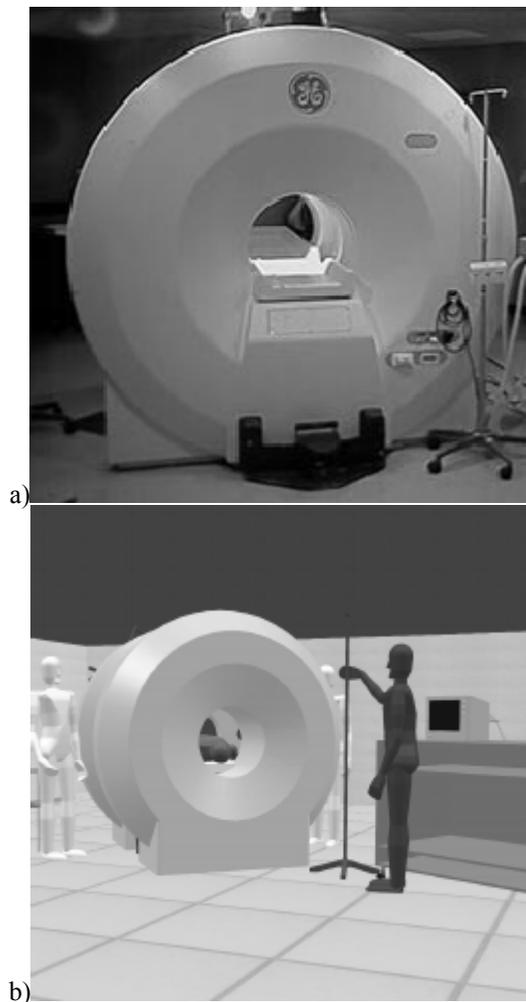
(a) View of open MRI at Surgical Planning Laboratory, Brigham and Women's Hospital (Boston, MA); (b) view of virtual operating room
